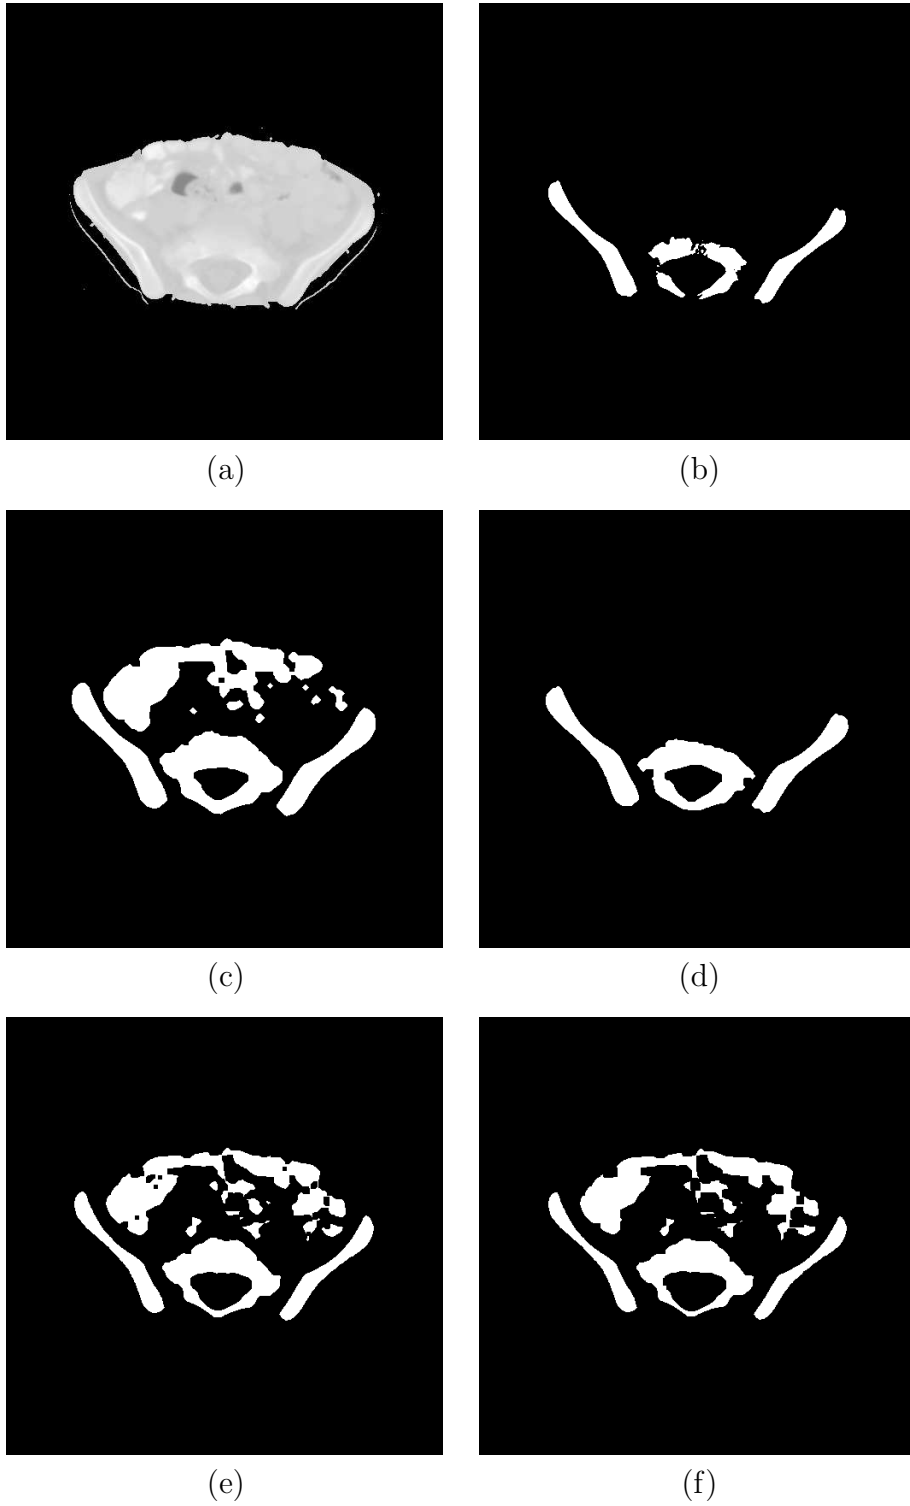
(a) A 512×512 CT slice after removal of air, skin, fat and muscle. Only one cross section is shown from an exam with 71 slices. (b) Mask obtained by Method-I; (c) Mask obtained by Method-II; (d) Mask obtained by Method-III; (e) Mask obtained by Method-IV; (f)Mask obtained by Method-V.
